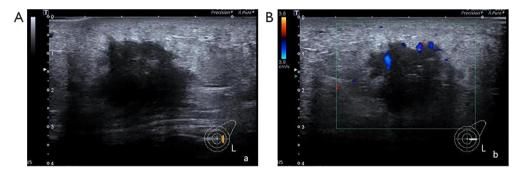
Ultrasound results from a 57-year-old patient with IDC. (A) Two-dimensional ultrasound showed the lesion with irregular shape, spiculated, and angular margin, hypoechoic pattern, and posterior shadows; (B) the vascularity grade of IDC was grade II. IDC, invasive ductal carcinoma.
